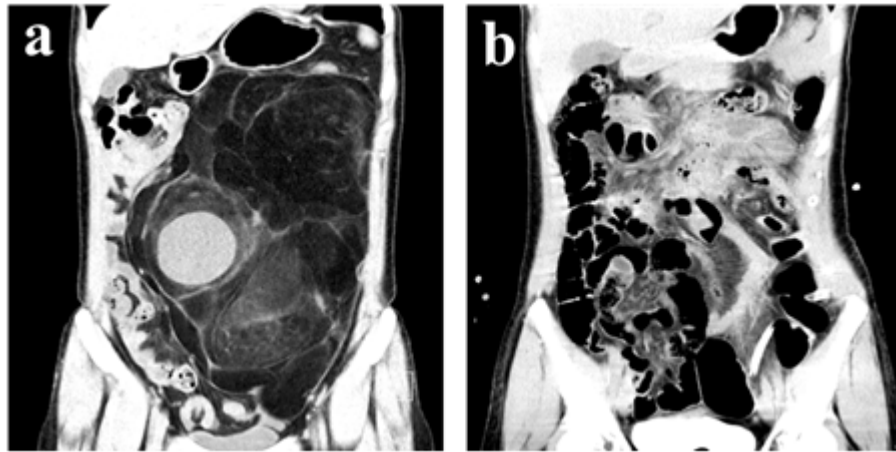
Postoperative contrast-enhanced CT.
